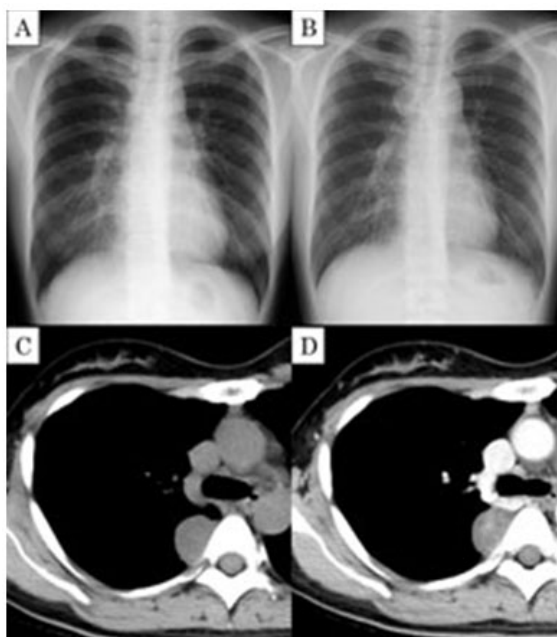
Chest radiography and computed tomography in case 1. (A, B) Abnormal shadows exhibiting apparent growth over 6 years in the right first cardiac arch. (C, D) A well-defined and heterogeneously enhanced tumor (size: 3.5 cm) in the right posterior mediastinum.
